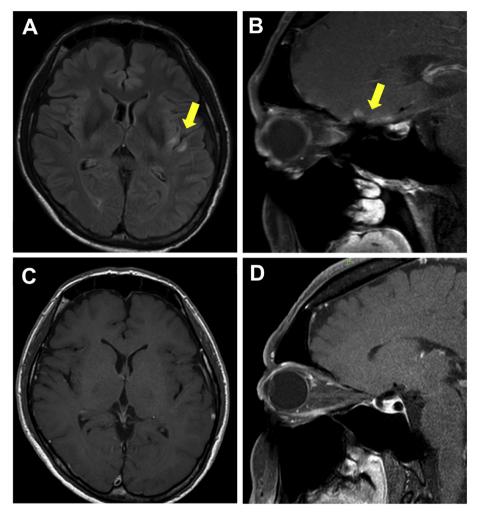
Multiple brain lesions on magnetic resonance imaging.
